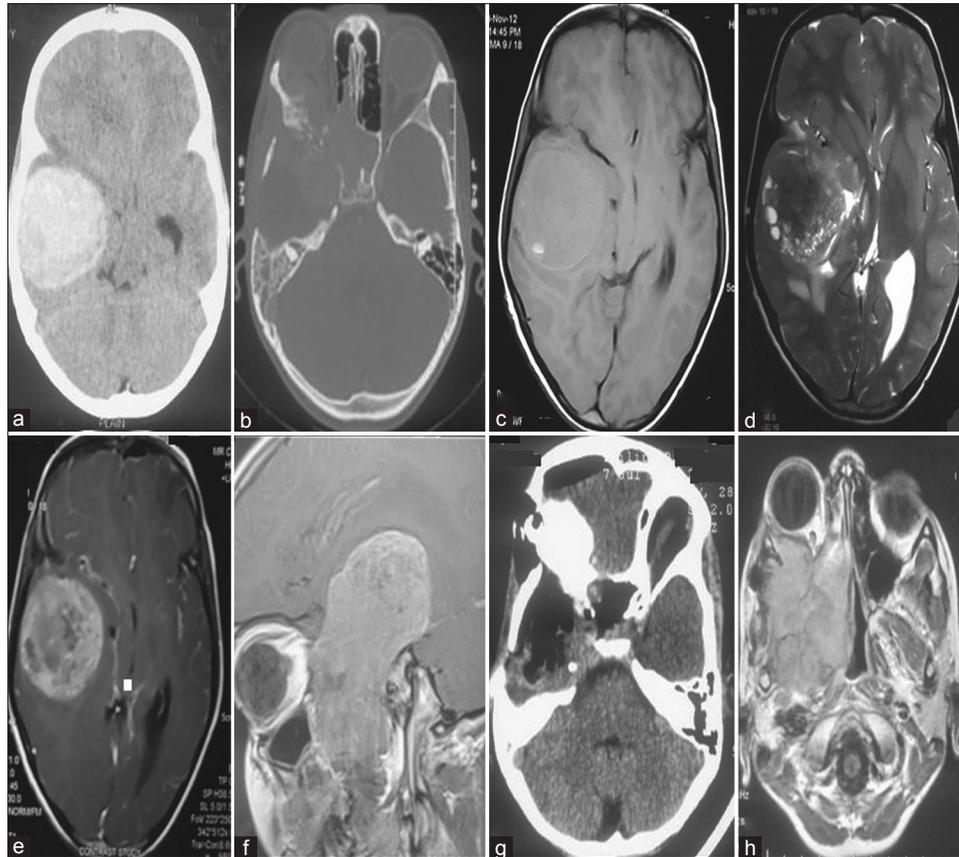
(a and b) Noncontrast computed tomography showing dural-based hyperdense lesion in infratemporal fossa and extra-axial temporal region with bony destruction, (c) T1-weighted magnetic resonance imaging-isointense, (d) T2-weighted magnetic resonance imaging-hypointense lesion, (e and f) heterogeneous contrast enhancement, (g) complete removal after surgery in postoperative contrast-enhanced computed tomography, (h) recurrence of lesion after 1 year in infratemporal fossa and paranasal sinus seen in contrast magnetic resonance imaging
